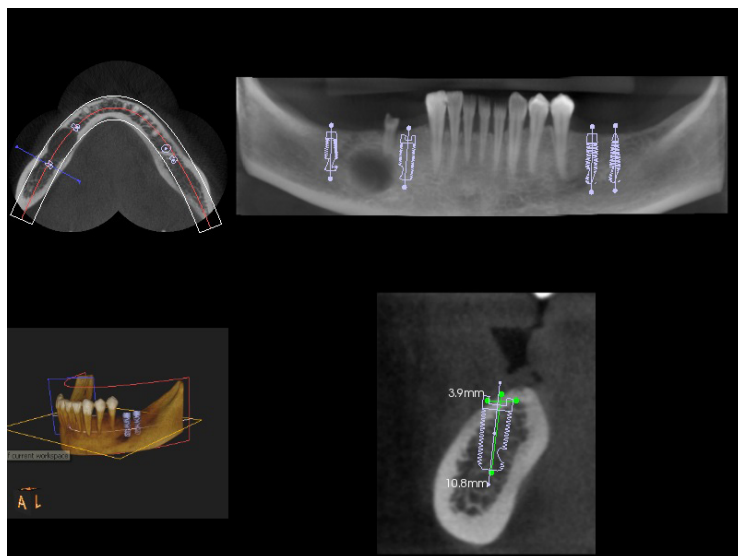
CBCT scan of a patient with a radicular cyst on the body of the mandible (anterior, superior and lateral view), 3D reconstruction, showing the future location for the implants.
